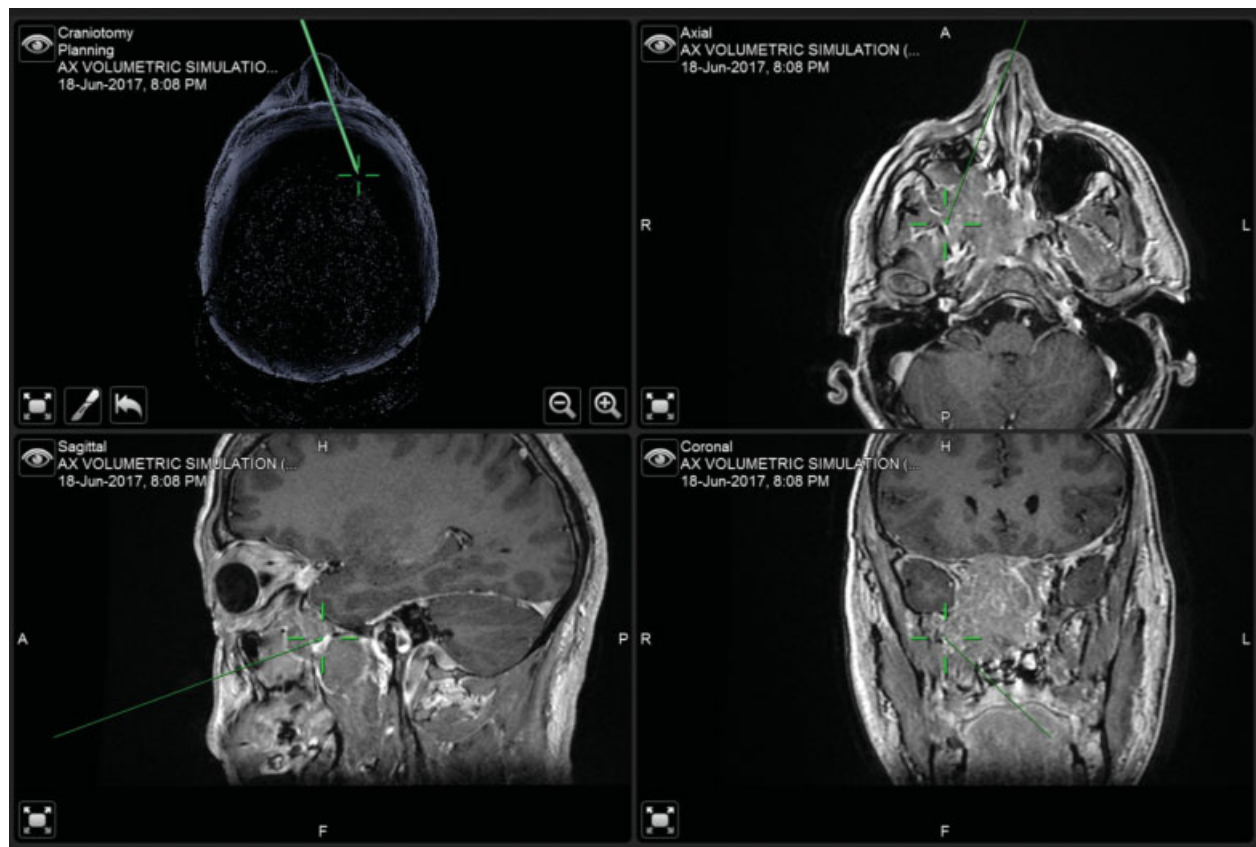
Intraoperative image guidance with multiplanar MRI and 3D images. 3D, three-dimensional; MRI, magnetic resonance imaging.
